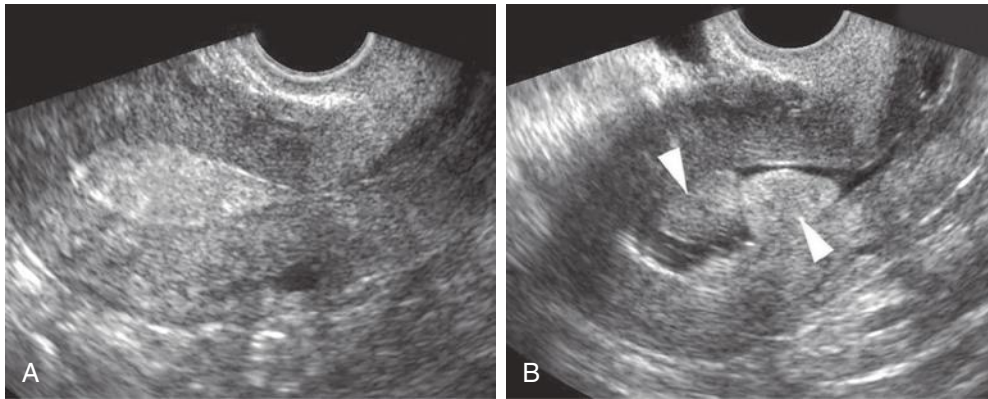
A 62-year-old woman with postmenopausal bleeding. A, Transvaginal longitudinal ultrasound image of the uterus shows diffuse echogenic thickening of the endometrium. B, Longitudinal saline infusion sonohysterography (SIS) shows two echogenic polypoid masses (*arrowheads*) with otherwise normal thin endometrium. SIS is helpful in triaging patients with diffuse endometrial thickening to blind biopsy or, in the case of a focal abnormality as shown here, to hysteroscopic removal.
